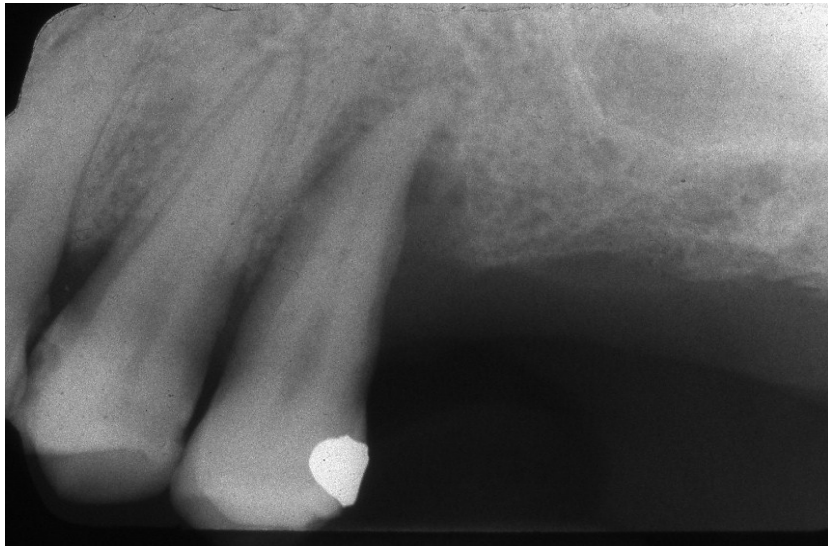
Periapical radiograph that supports diagnosis of severe periodontal disease involving the second bicuspid (1992)
